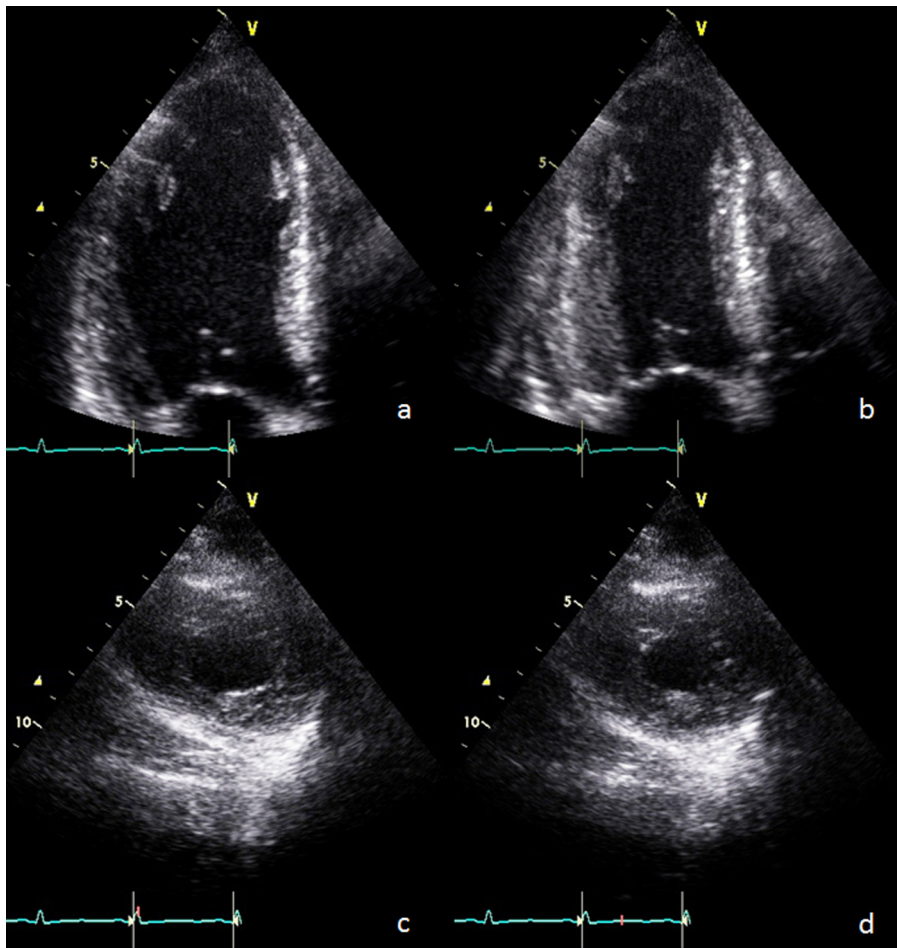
Second echocardiograph: (a) apical 4 chamber echo images diastole and (b) systole demonstrates akinetic to dyskinetic apex while basal left ventricular (LV) demonstrates systolic change in LV dimension. (c) Apical short axis images demonstrate no change in LV apical dimension from diastole to (d) systole indicating apical akinesis.
